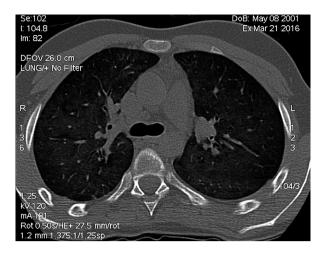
High-resolution chest CT scan performed in the acute phase showing diffuse ground glass areas in both lungs.
